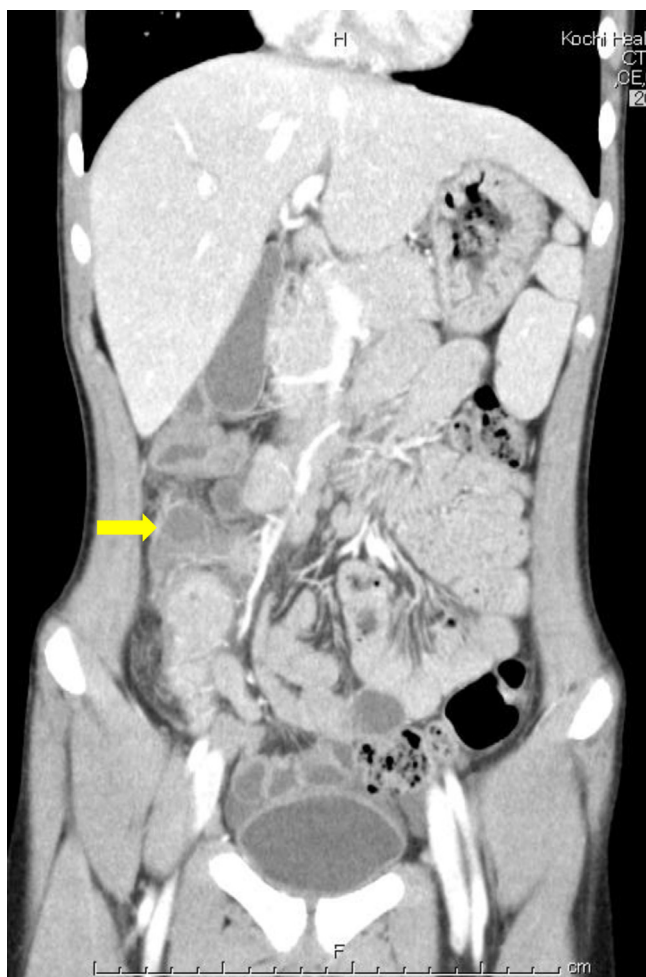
Preoperative findings. Coronal view of contrast-enhanced computed tomography revealed wall thickening of the well enhanced terminal ileum and fluid collection with a contrast-enhanced wall at the ventral side of the ascending colon.
